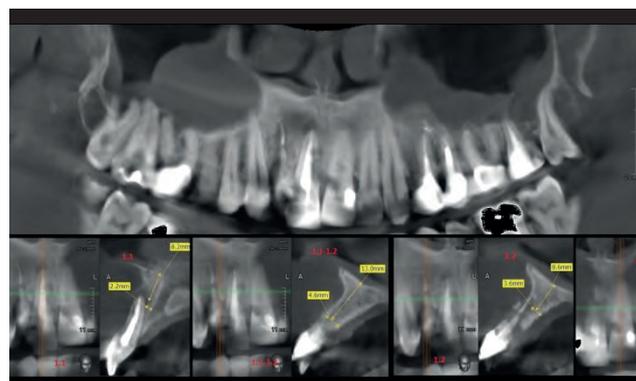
A. Intraoral view of the patient B., 25 years old on admission. B. CBCT-visualization of the maxilla.
